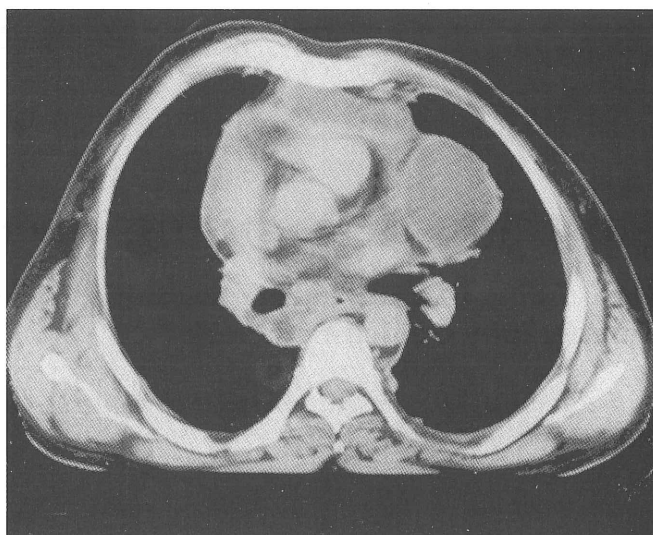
Thorax computed tomography at time of admission: multiple paramediastinal cystic masses and widened mediastinum.
